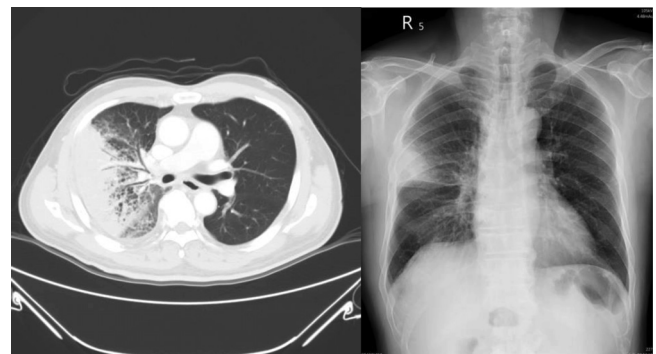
A. Chest radiograph of the patient. B. Computed tomography of the chest during hospitalization.
